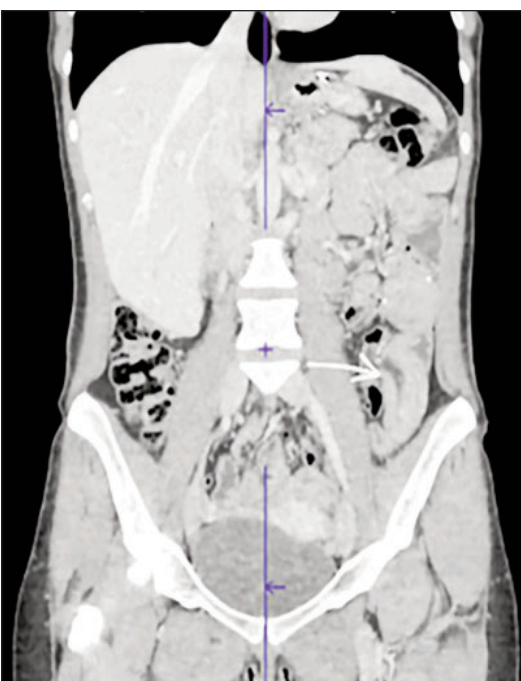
Abdominal CT scan image who reveals the bowel intussusception in the left flank
